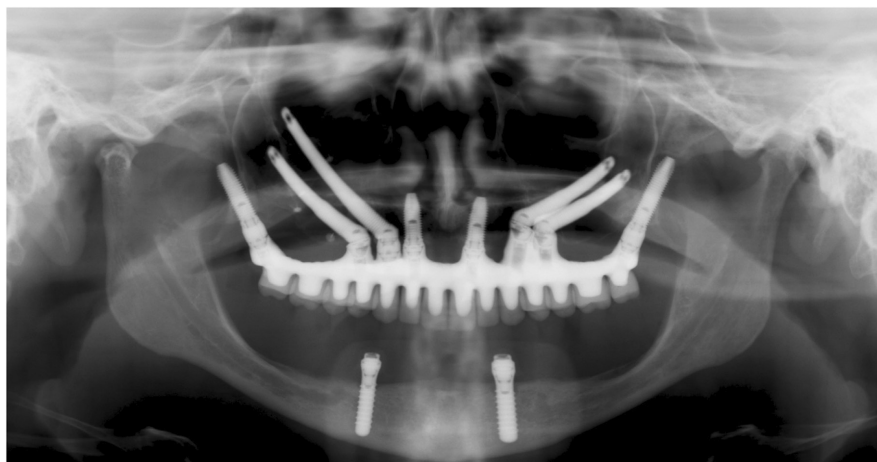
Orthopantomograph showing the combined use of zygomatic and pterygoid implants to support a full-arch implant-supported fixed dental prosthesis. (Adapted with permission from Avila-Ortiz et al.¹).
